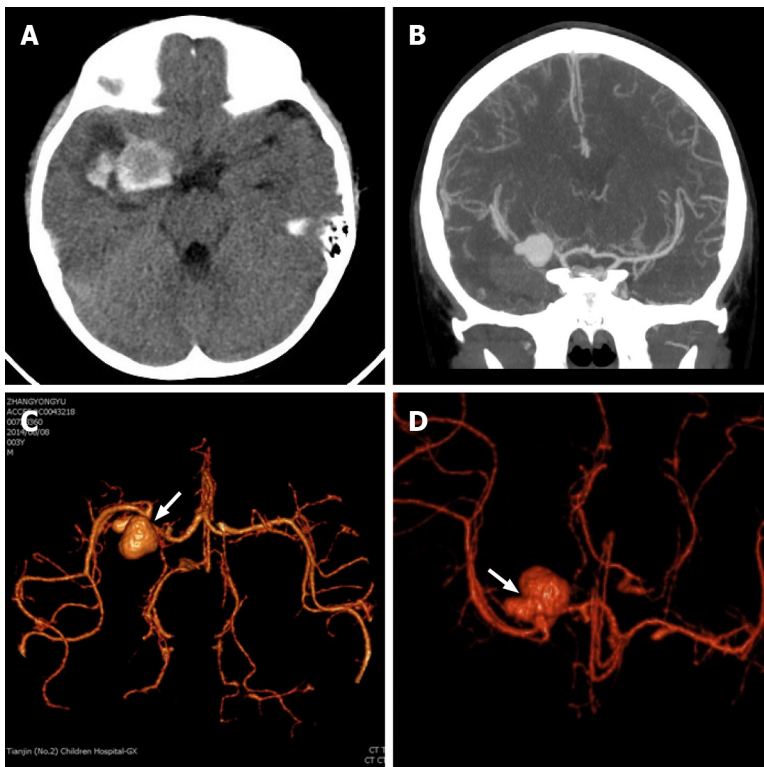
Preoperative imaging examination. A: Subarachnoid hemorrhage caused by ruptured intracranial dissecting aneurysm (IDA); B: Computed tomography angiography shows intracranial aneurysm in the right medical council on alcohol; C and D: Pearl-and-string sign of IDAs (focal stenoses proximally and distally, which are noted by white arrows).
